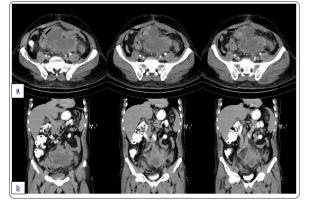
Abdominal CT scan, note tumor and its adhesions to adjacent structures. a) axial view b) coronal view
